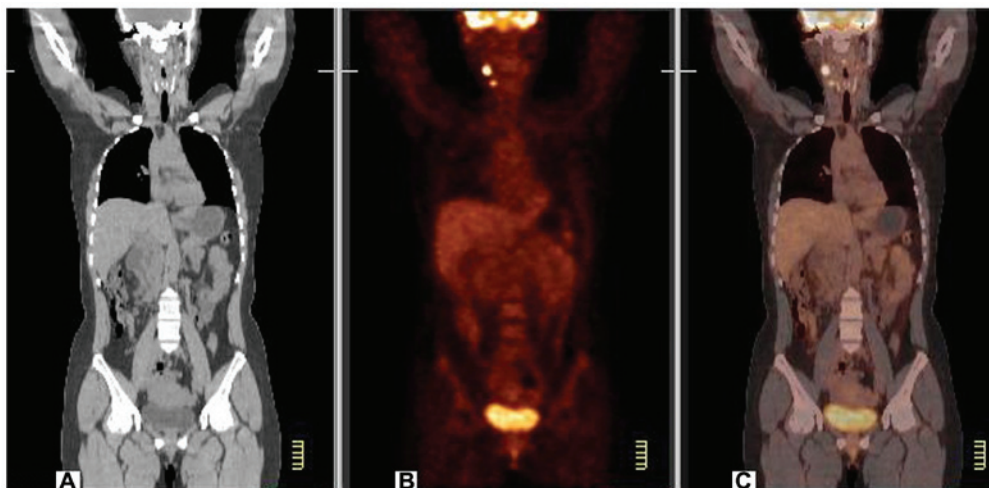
Cervical lymph node metastasis revealed by positron emission tomography/computed tomography (PET/CT) scanning. (A) CT imaging shows no significant neck mass. (B) PET imaging shows two lumpy abnormal radioactive concentration shadows on the right side of the neck. (C) PET/CT imaging shows two abnormal fluorodeoxyglucose hypermetabolism areas in the sternocleidomastoid region of the right side of the neck, which were considered lymph node metastases.
